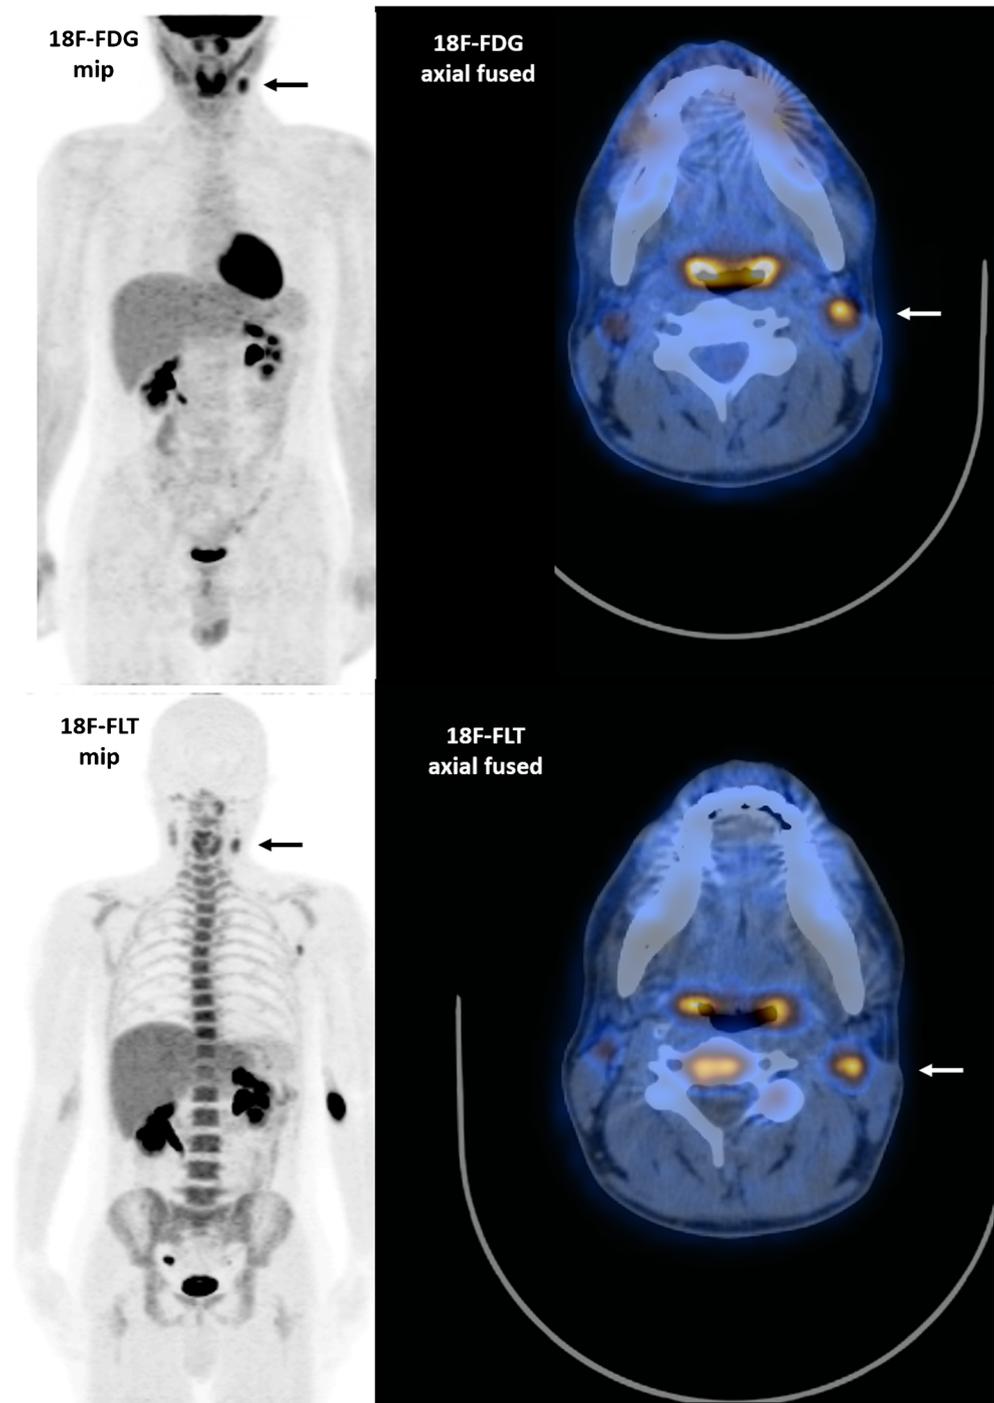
Suspected para-pharyngeal and laterocervical HL relapse: false-positive FDG and true-negative FLT in dental inflammation. 18F-FDG was suspicious for HL relapse at the level of the left para-pharyngeal space (SUVmax = 7; TBR = 3.9, original site of disease at diagnosis) and bilateral cervical nodes (black arrow in mip, SUVmax = 4.1 right;
